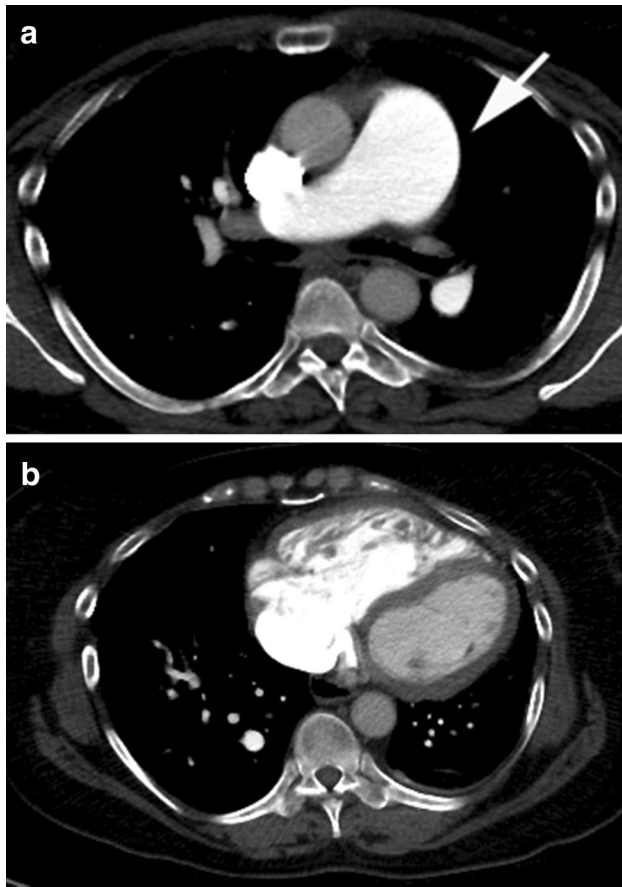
62-year-old woman with CTPEH. a Axial chest CT demonstrates a dilated main pulmonary artery (arrow) which is suggestive of pulmonary hypertension. b Axial chest CT demonstrates right ventricular dilation and hypertrophy
